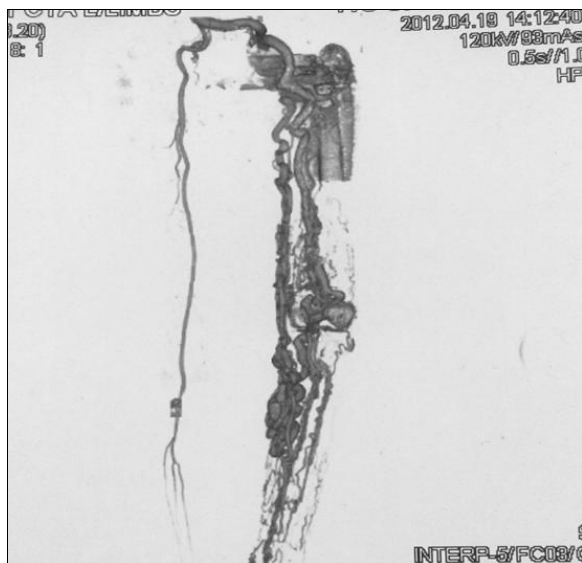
CT angiography. Inflicting cause was forgotten dagger injury.
